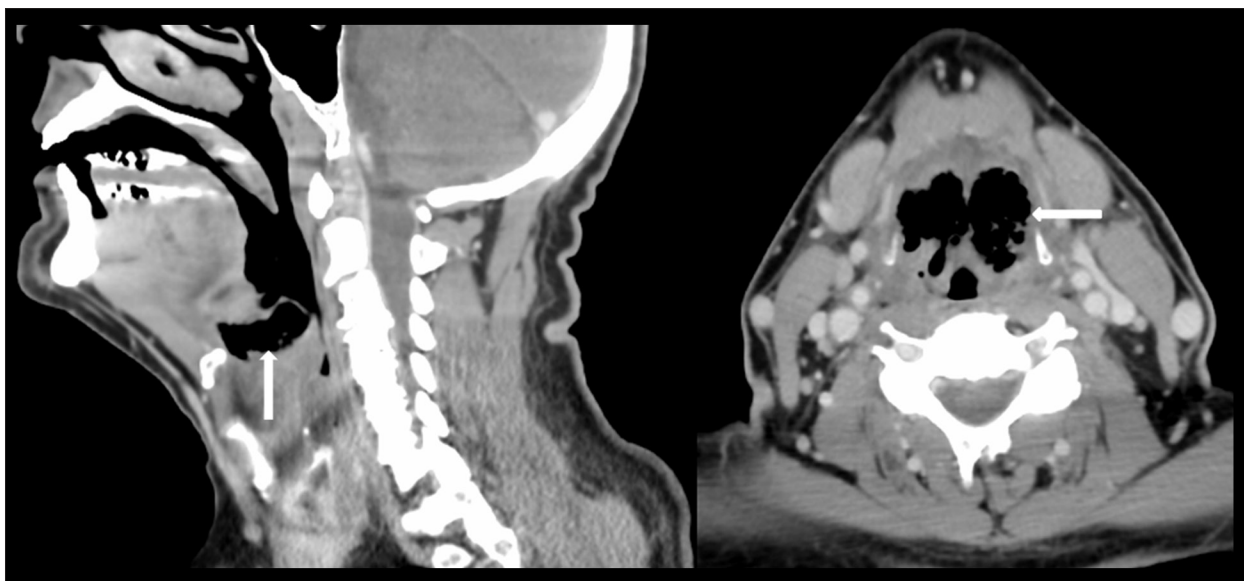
Contrasted CT of the neck showing submucosal emphysema (arrows) of the lingual surface of the epiglottis in sagittal and axial planes.
